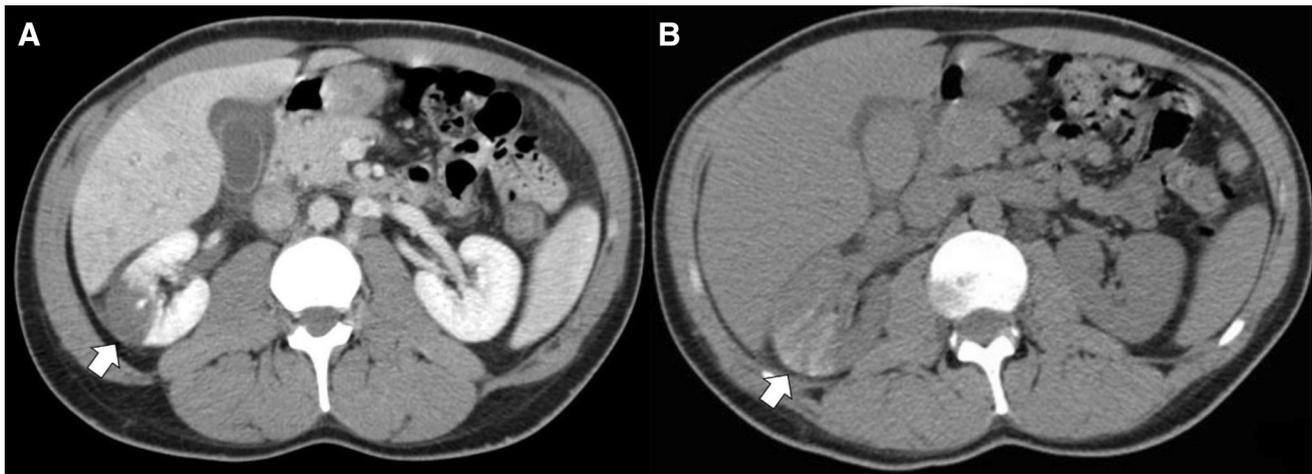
Acute renal infarction of right kidney in a 32-year-old man. a Axial CT image on nephrographic phase shows a wedge-shaped parenchymal defect (arrow) that involves both the cortex and medulla and extends to the capsular surface. b Corresponding axial CT image
